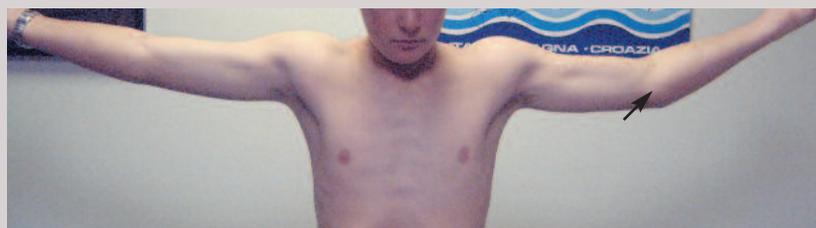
a (top) Avulsion fracture of the left medial humeral epicondyle (arrow) in an elite 14-year-old male baseball pitcher caused by an acute on chronic mechanism. b (left) X-ray showing fracture (arrow). c (right) Follow up x-ray showing healing and remodelling of the medial epicondyle (arrow) 6 months after treatment, which included physiotherapy, relative rest, cross-training and graded return to sport. Errors in his pitching technique were also addressed to help minimise the risk of future injury.
